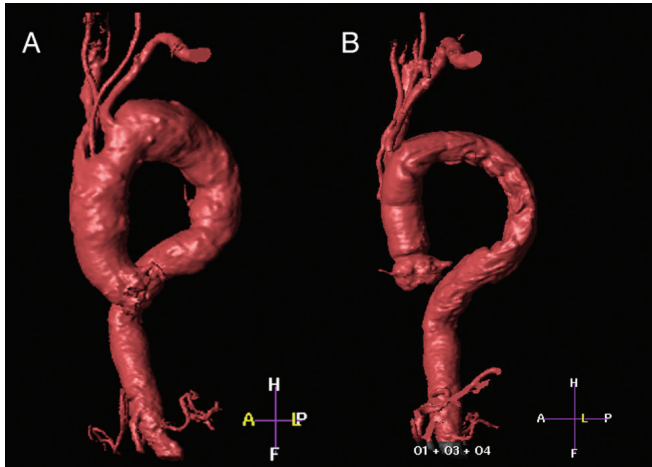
(A) Preoperative and (B) postoperative magnetic resonance imaging of a patient undergoing aneurysm hybrid treatment with simultaneous replacement of the ascending aorta and aortic arch and endoluminal stenting of the descending aorta.
